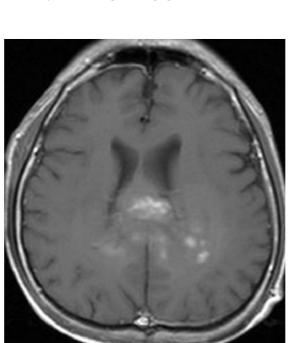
Contrast-enhanced T1-weighted image. The image above demonstrates a butterfly glioblastoma pattern in a MRI image (Image as originally published in Urbańska *et al.*, 2014. License: Termedia, 2014, Creative Commons Attribution-Noncommercial 3.0 Unported).
